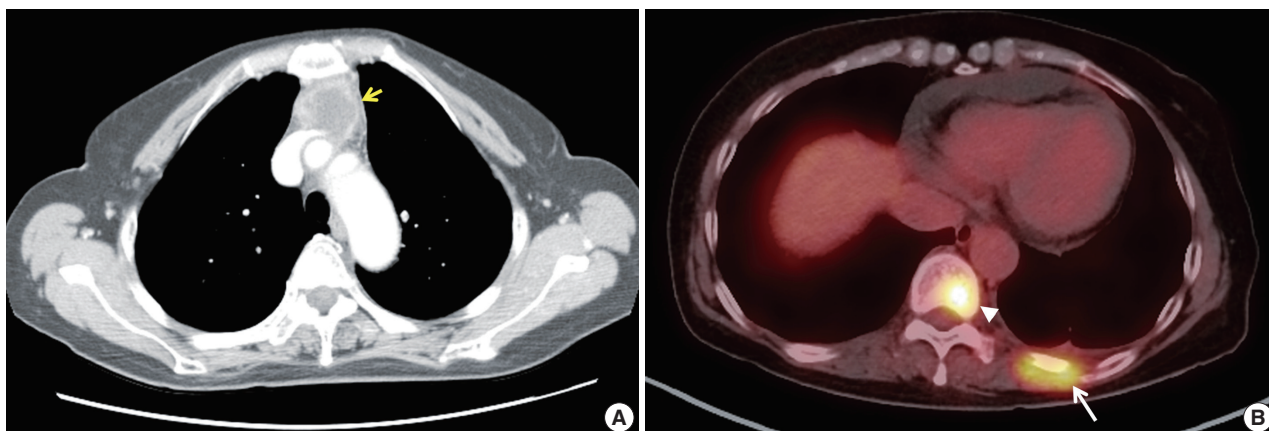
Radiologic examination of the anterior mediastinum. (A) An irregularly enhancing mass (arrow) in the anterior mediastinum on a chest computed tomography scan. (B) Abnormal hyperuptake in lesions at the 10th vertebra (arrowhead) and the left 10th rib (arrow) on a whole-body positron emission tomography scan.
